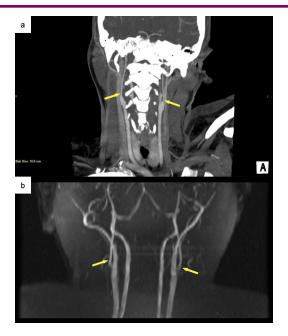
(a) CT angiography of the neck, 3D MIP coronal reconstruction, demonstrating markedly reduced caliber of the bilateral internal carotid arteries (yellow arrows) (b) MR angiography of the neck, 3D MIP coronal view, similarly showing reduced caliber of the internal carotid arteries (yellow arrows), with greater signal reduction noted to the left.
